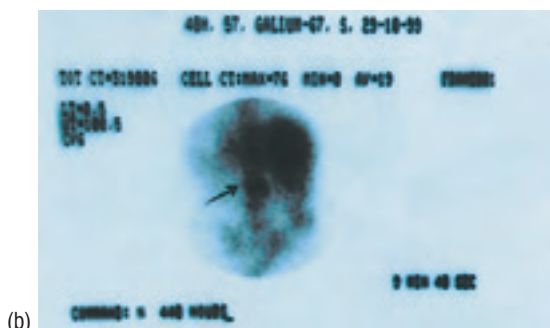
A patient with suspected post-operative infection in the upper part of the right femur. (a) Bone scans with ^{99m}Tc-MDP and (b) with ^{99m}Tc(V)DMSA, showed an increased uptake in the upper part of the right femur, while (c) ⁶⁷Ga-citrate scintigraphy showed a slightly increased uptake (false negative case) Final diagnosis: osteomyelitis
